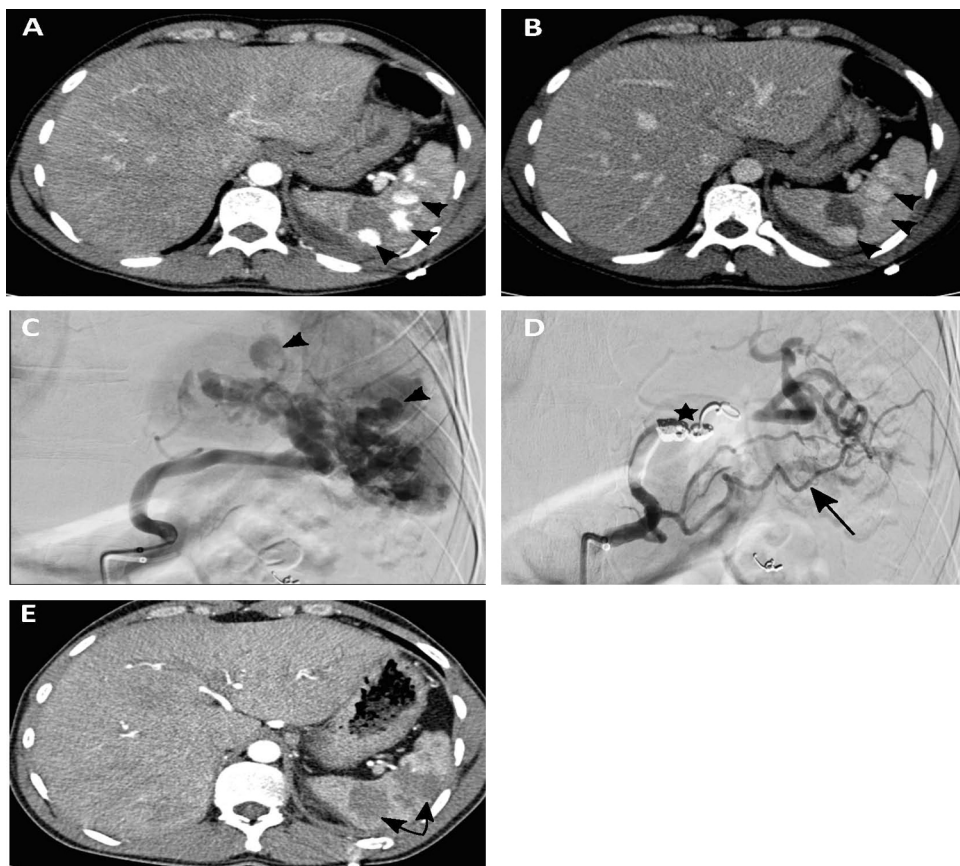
Embolization for splenic trauma. A 29-year-old patient hospitalized for abdominal trauma sustained in a ski accident with AAST grade III splenic trauma and AAST grade 4 renal injury, without active bleeding on initial total body CT, was managed by non-operative treatment. On day 5, a control CT showed multiple sacular enhanced arterial images compatible with intra-splenic false aneurysms (arrowhead image A), preserving the contrast material during the venous phase without changing shape (arrowhead image B). Arteriography showing multiple intra-splenic false aneurysms (arrowhead image C). Because of the large number of aneurysms to treat, and in order to avoid extensive necrosis of the spleen, proximal coil splenic embolization was performed (star image D). Note the segmental thrombosis of the artery near the coils and revascularization of the distal portion of the artery via the pancreatic arcades (arrows image D). On day 10, follow-up CT showed that all the false aneurysms were thrombosed (double arrows image E) while splenic parenchyma remained well-perfused.
